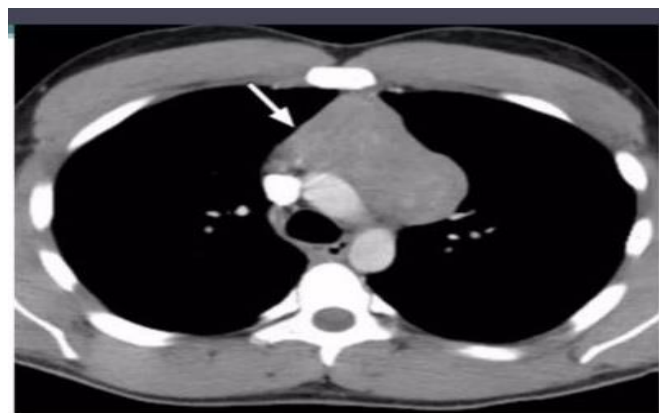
PET CT showing anterior mediastinal mass measuring 13.4 x 12.5 x 8 cm.
